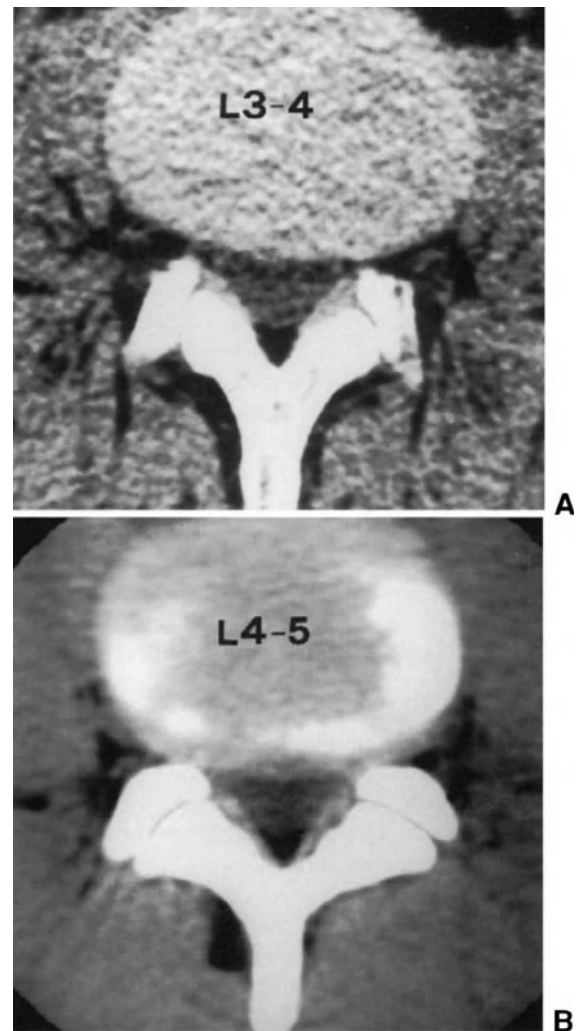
Axial CT scans at L3-L4 (A) and L4-L5 (B) levels showing a bulging annulus fibrosus. The posterior border of the L3-L4 disc, which is normally rectilinear or concave, appears to be convex. At L4-L5 level, the posterior border of the disc exceeds the limits of the vertebral endplate.
